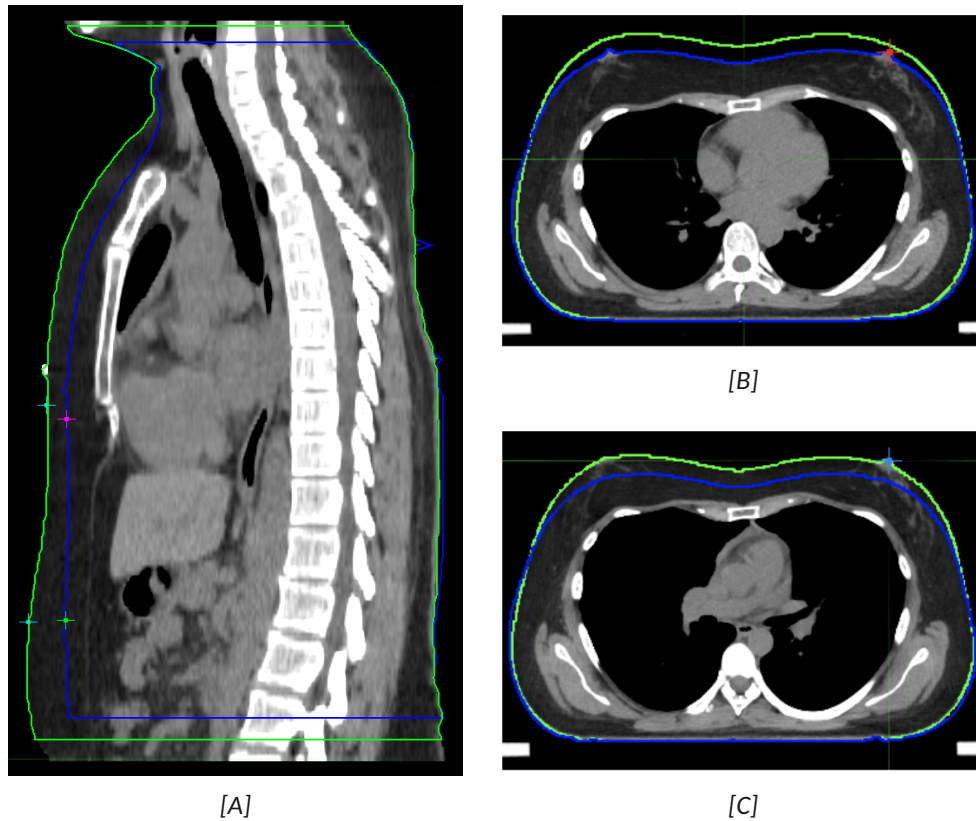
[A] Coronal CT view of abdominal and xiphoid process points on both the free breathing (“Body FB”, blue contour) and breath hold (“Body BH”, green contour) surfaces.
